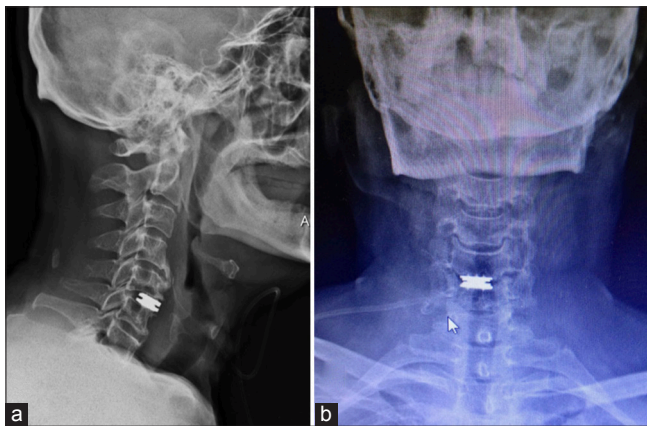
Radiological images of the patient demonstrating the (a) Lateral X-ray image post-anterior cervical disc arthroplasty (ACDA) surgery showing the initial positioning of the prosthesis. (b) Anteroposterior view post-ACDA surgery demonstrating correct placement of the prosthesis (white arrow).
